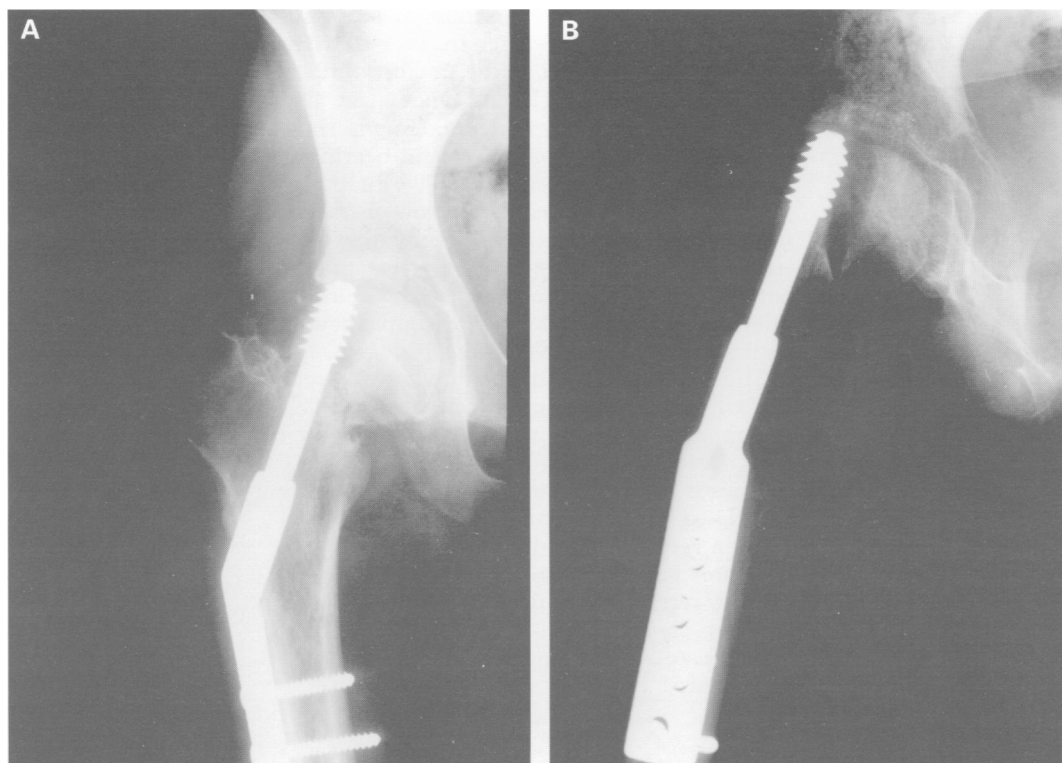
Anteroposterior (A) and lateral (B) radiographs showing failure of fixation with the dynamic hip screw cutting out anterosuperiorly.
